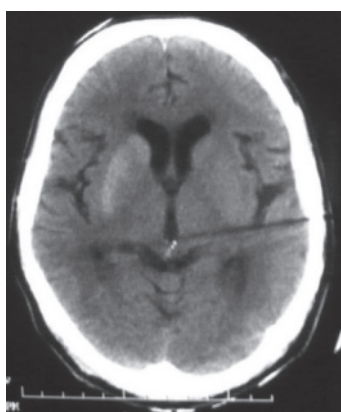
CT Brain showing hyper-densities in the right putamen and caudate nucleus (Patient 1)
